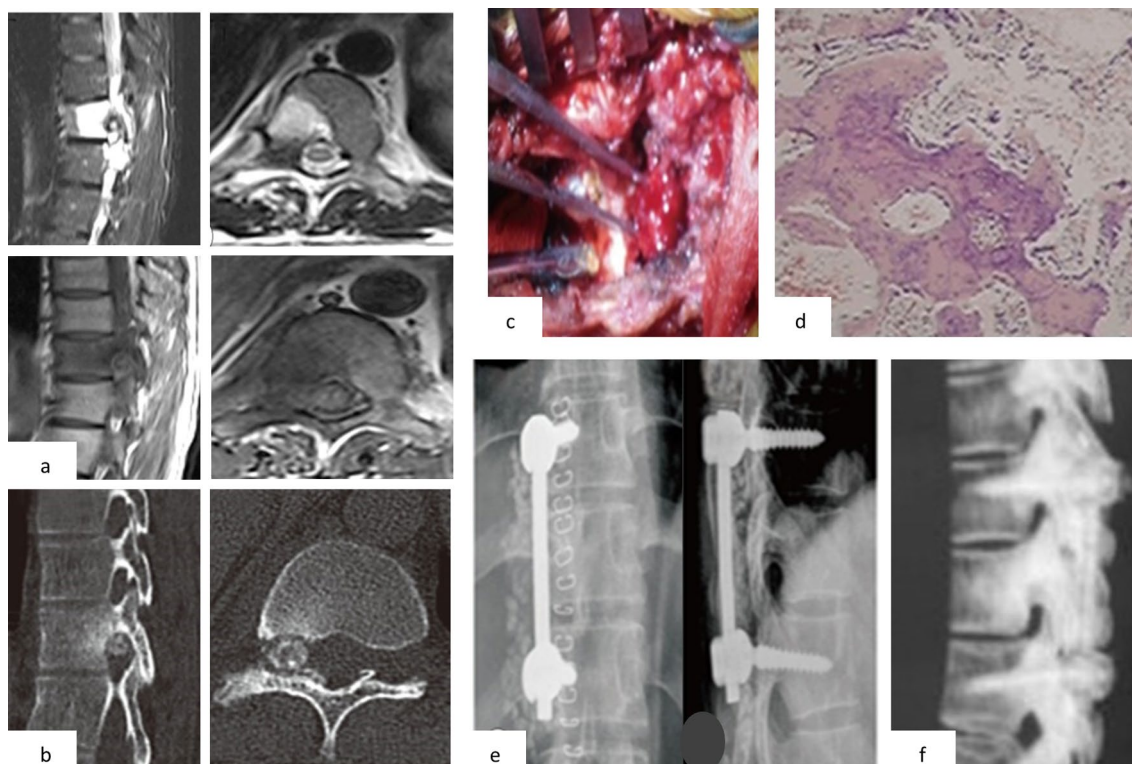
Case 1 a T1w and T2w MRI showing extraosseous foraminal lesion with vertebral body edema, b CT sagittal and axial section showing extraosseous lytic lesion with sclerotic rim in neural foramen, c excised tumor mass, d HPE slide confirming osteoblastoma, e Post-operative AP and lateral X-ray confirming implant positioning, f 5 years follow-up CT scan showing fusion
